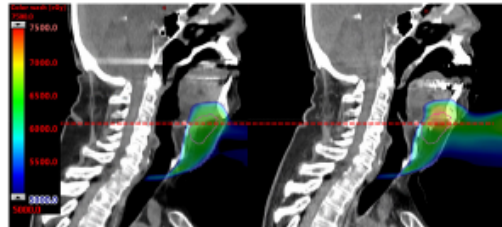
(a) Sagittal view of planning CT patient six with CTV1 contour and (b) corresponding slice of the first vCT-calculated nominal plan. The hotspot is attributed to differences in the jaw position (shown by the dashed red reference line) and the setup variation of the posterior neck region. CTV, clinical target volume; vCT, virtual CT.
